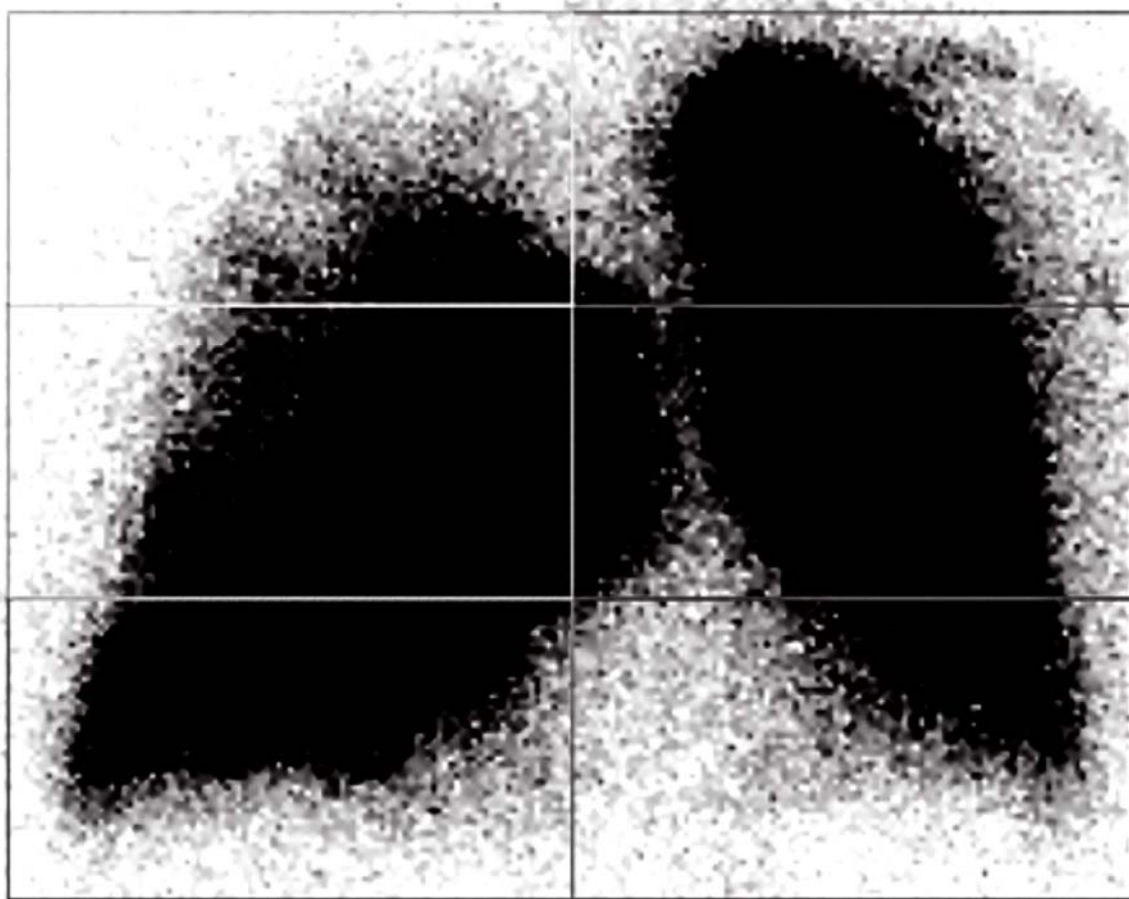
Example of inadequate segmentation on planar scintigraphy due to right lung parenchyma overlying midline. There is also prominent vascular activity, partly included in left upper and left middle lung regions (anterior view showed, image contrast increased).
